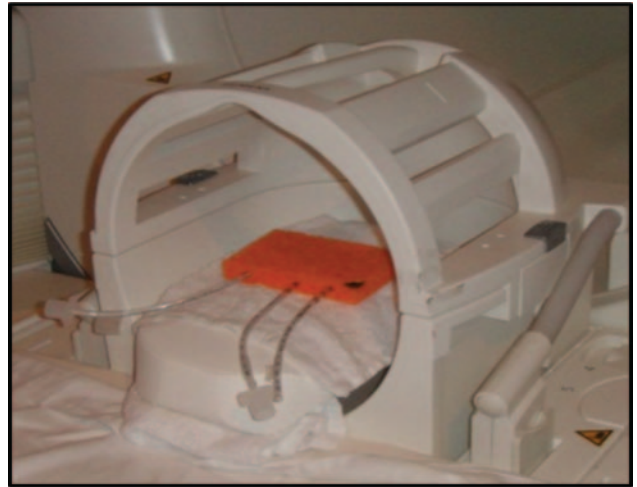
A single sponge with 3 endotracheal tubes placed in a 12 channel head coil for magnetic resonance imaging. A black mark at the right upper corner of the sponge ensures consistent placement between scans; the endotracheal tubes are marked with clear tape to indicate the ventilator they are connected to during aerosol administration.
